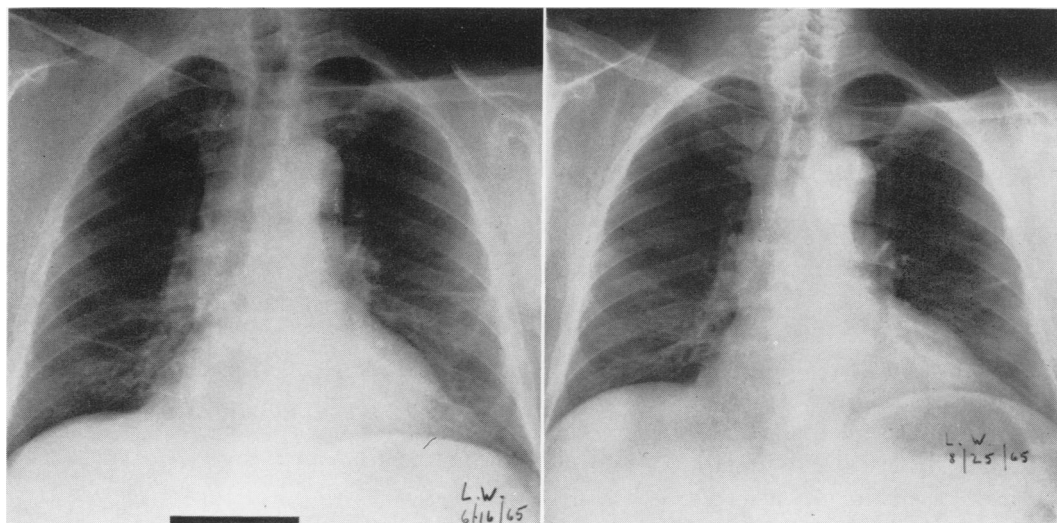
Chest roentgenograms prior to and at eleventh week of treatment.
